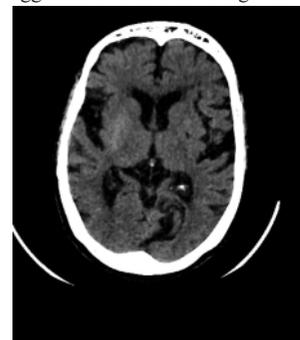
CT brain image of a 70 years old female with acute left
